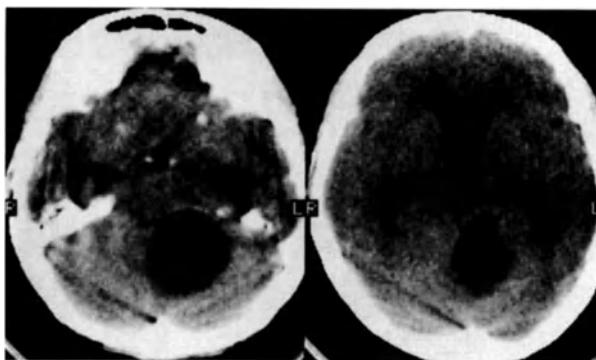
CT of cystic hemangioblastoma. The vascular tumor nodule can easily be missed in these cases.
